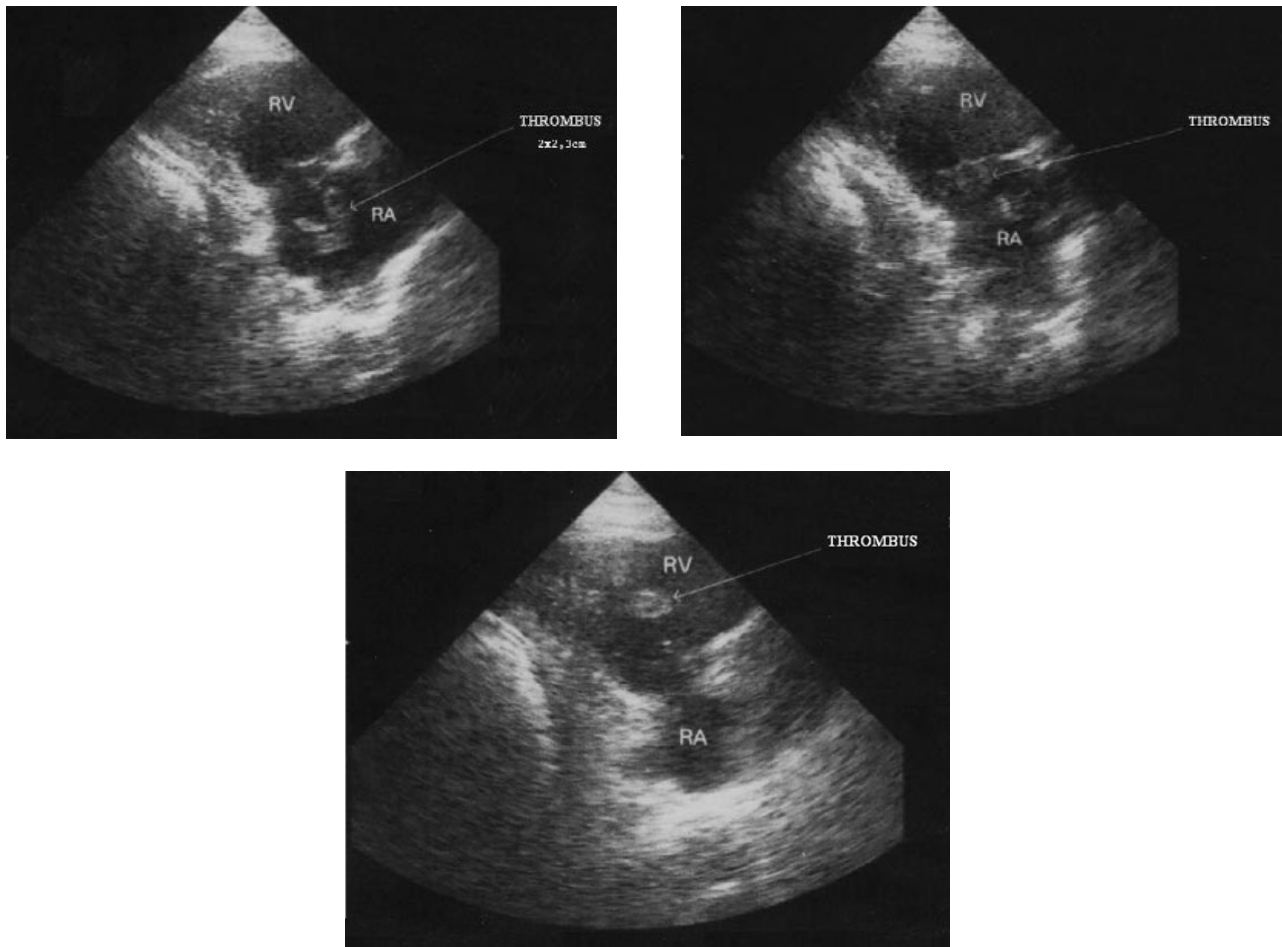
The real-time images disclosing the acute pulmonary embolism. Modified transthoracic echocardiographic view showing a three-lobular and mobile thrombus 2x2.3 cm in diameter moving freely in the right atrium (Figure 1), the passage of the thrombus from the right atrium into the right ventricular cavity (Figure 2) and then into the right ventricular outflow tract (Figure 3).
